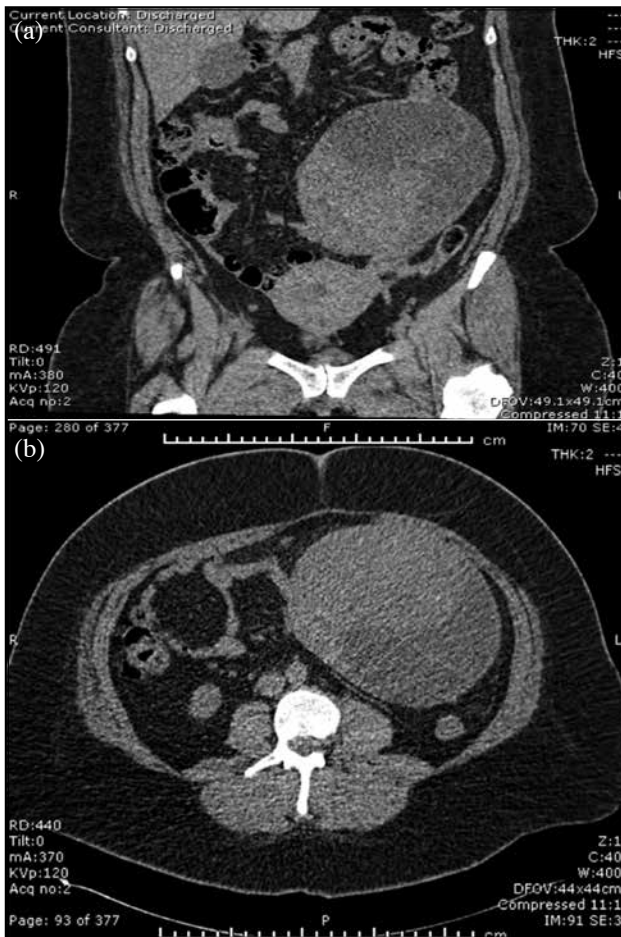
Computed tomography of the abdominopelvic area showing the left ovarian mass in (a) sagittal and (b) transverse view.
